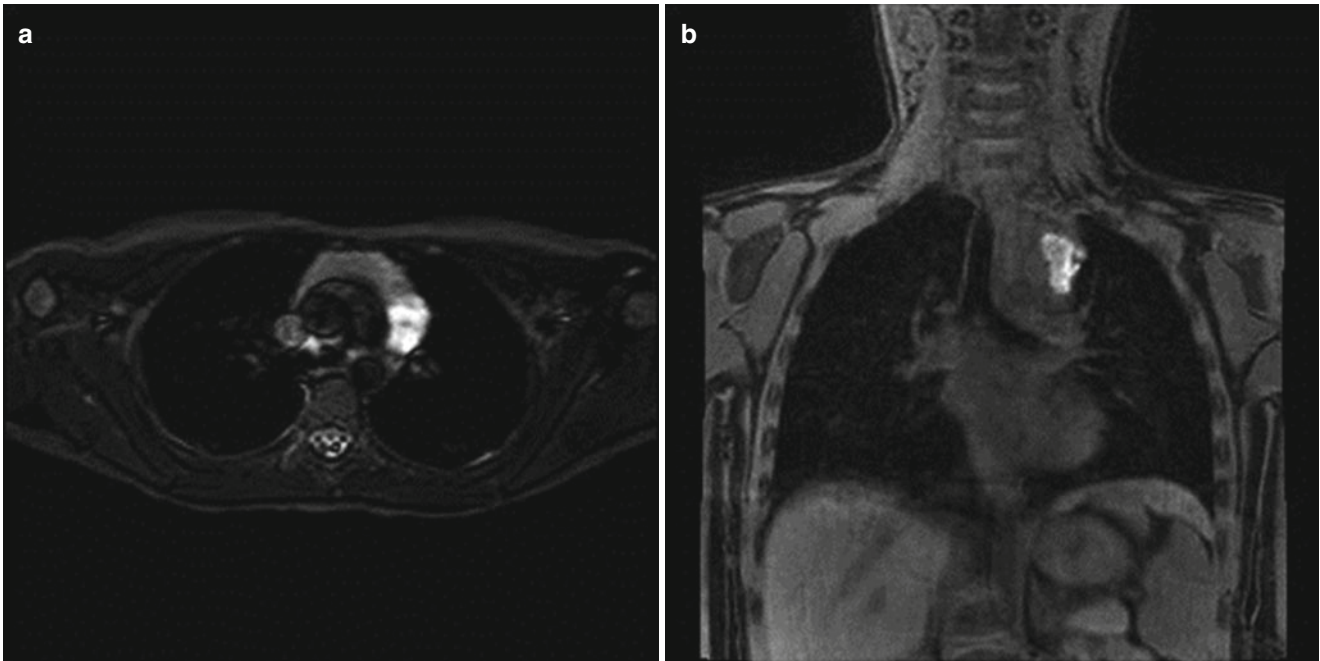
(a, b) A 7 year old girl had cervical lymphangioma resected 4 years previously. She had remained asymptomatic until she recently presented with prominent left neck and chest wall vessels. A MRI was performed to demonstrate the superior mediastinal mass compressing
